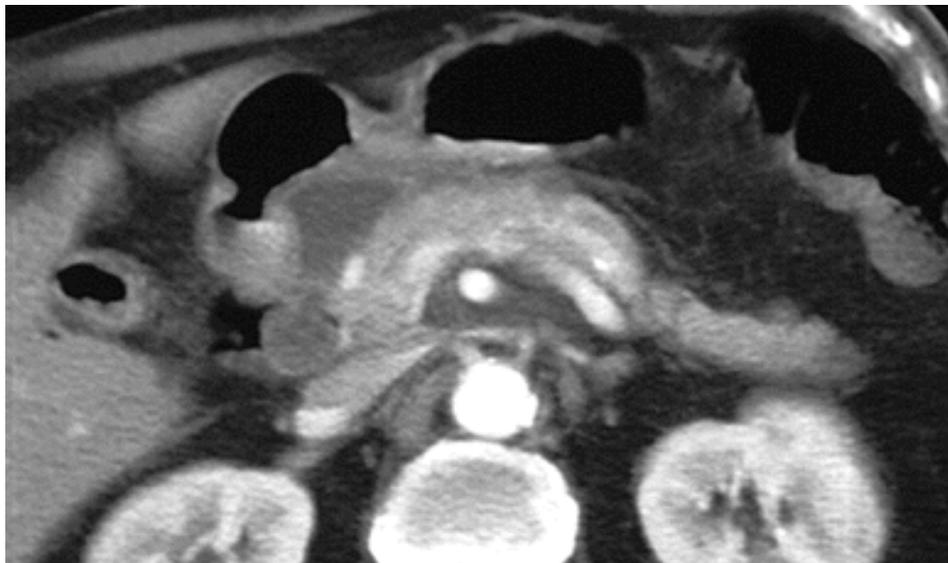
Severe form of acute pancreatitis seen in contrast enhanced CT of the abdomen.
